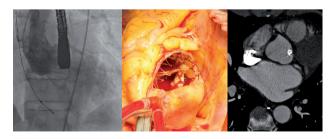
Left: Fluoroscopic image of the CoreValve prosthesis® with low aortic annulus implantation relative to the aortic annulus. Center: Image showing surgical explantation of the prosthesis. Right: CT angiography showing the degree of calcification of the aortic annulus.
